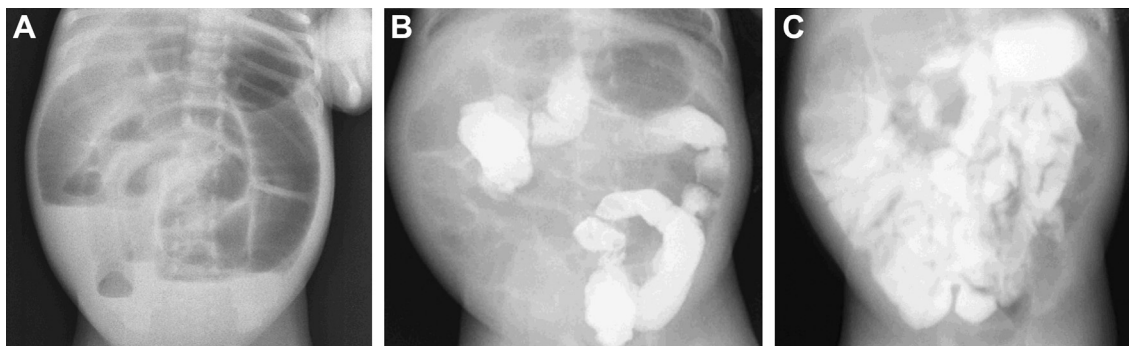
Case 1: (A) plain abdominal X-ray showing massive bowel loops distension; (B) barium enema demonstrating an undistended, normally rotated colon; (C) upper gastrointestinal series shows pooling of the contrast media in distal ileal loops.
